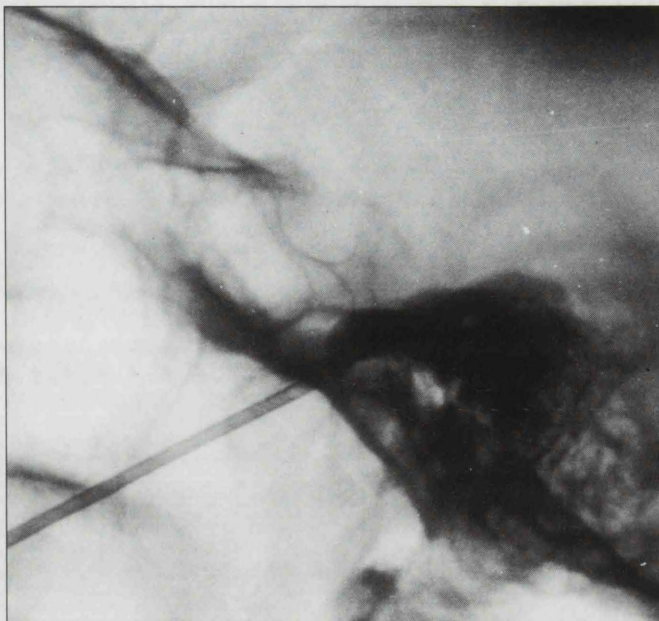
Lateral skull x-ray showing needle at margin of foramen ovale with the distorted Fogarty catheter balloon compressing the trigeminal ganglion.
